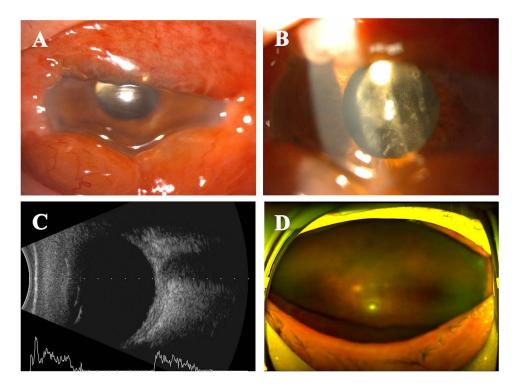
Indications of suspected endophthalmitis, I week postoperative. (A and B) The operated eye had obvious conjunctival chemosis, ciliary congestion, and a moderate intraocular reaction in the anterior chamber with grade 2+ cells and no hypopyon. (C) Mild infiltration by inflammatory cells in the vitreous identified with B-scan ultrasound. (D) The optic nerve and large retinal vessels could be seen, but other details of the retina were not visible under wide-angle fundus photography.
